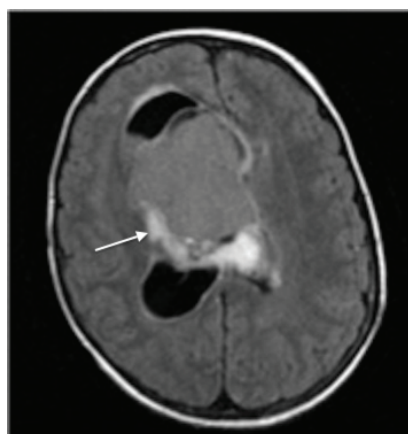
Axial FLAIR image of a woman with craniopharyngioma shows area of hyperintense perilesional brain edema.
